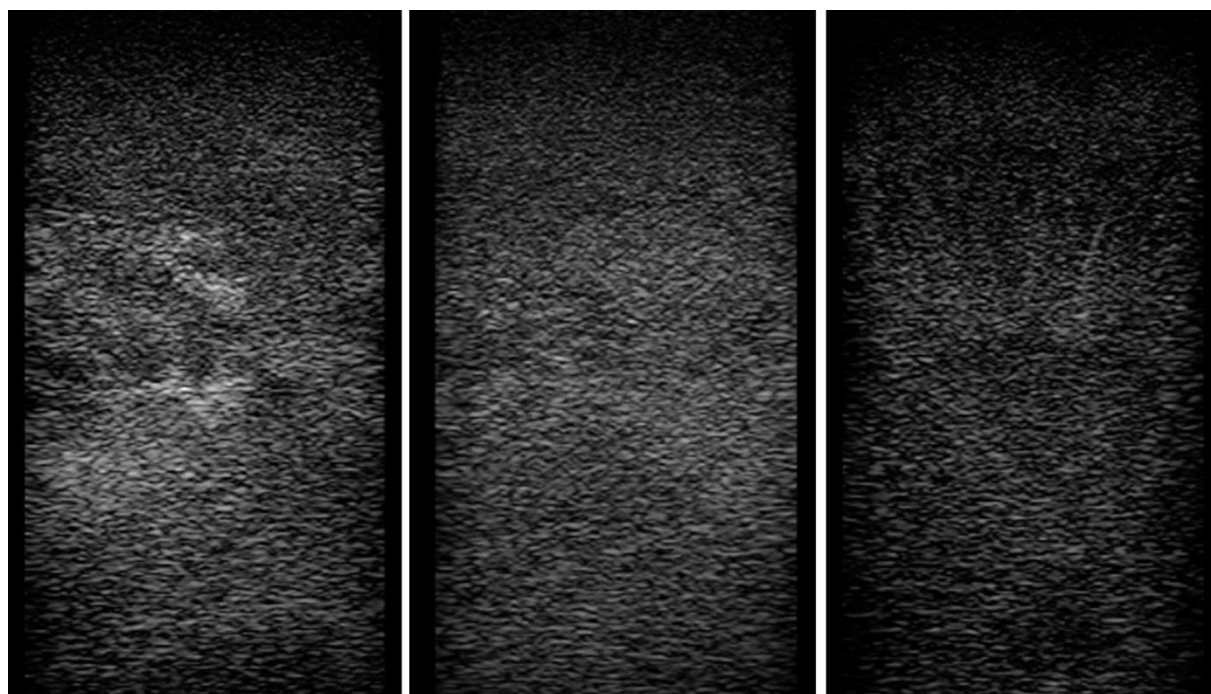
Ultrasound visualization PVA 4% 2FT: 3 images obtained with 5 cm penetration depth
